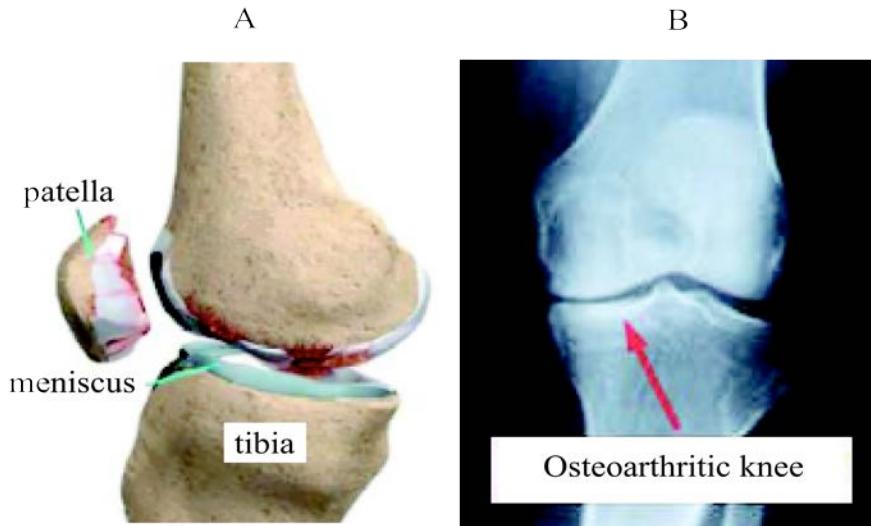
A. Osteoarthritis is due to the degeneration of the meniscus of cartilage between the femur and tibia. B. By X-ray this shows up as a narrowing of the space between the bones.^{6a}
